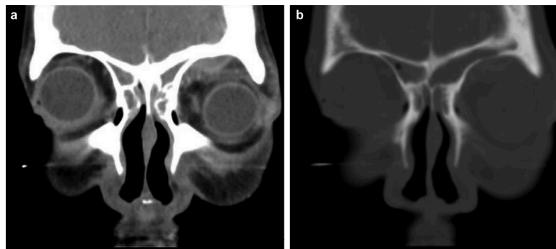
Computed tomography scan with intravenous contrast coronal cuts shows (a) left frontal sinus opacification with a subperiosteal abscess (1.3 x 1.6 x 0.5 cm) along the roof of the left orbit. (b) A small bone defect in the orbital roof can also be seen.
